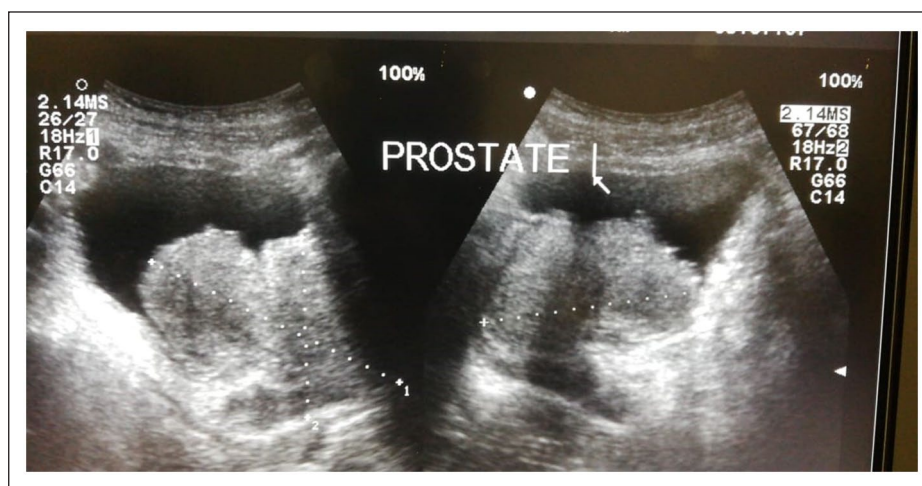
Transabdominal ultrasound of the prostate showing an inhomogeneous prostate gland measuring 120 ml.
